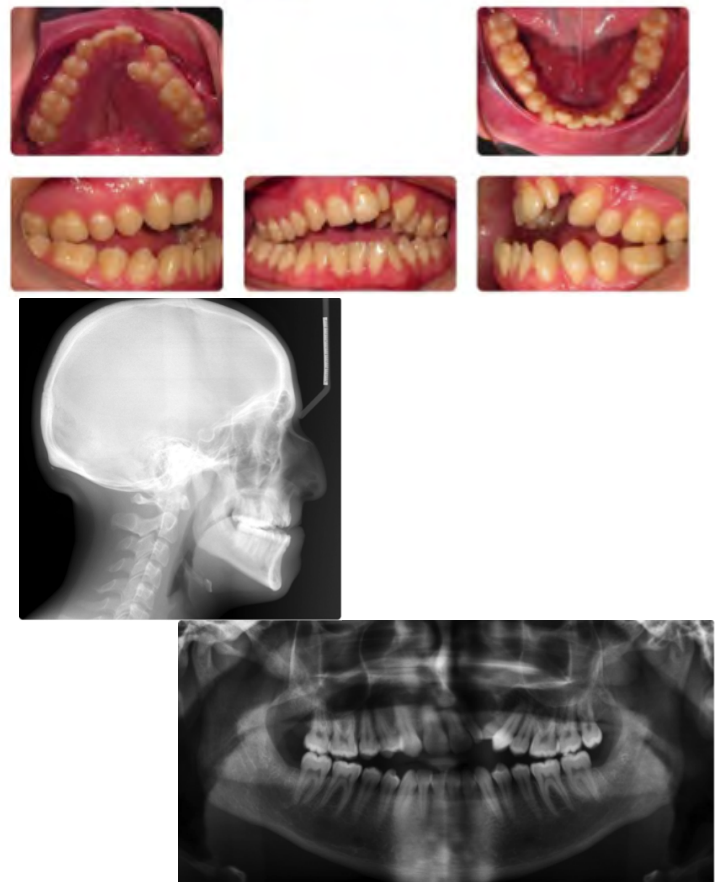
Initial intra- and extra-oral records, panoramic radiograph, and lateral cephalometric radiograph
